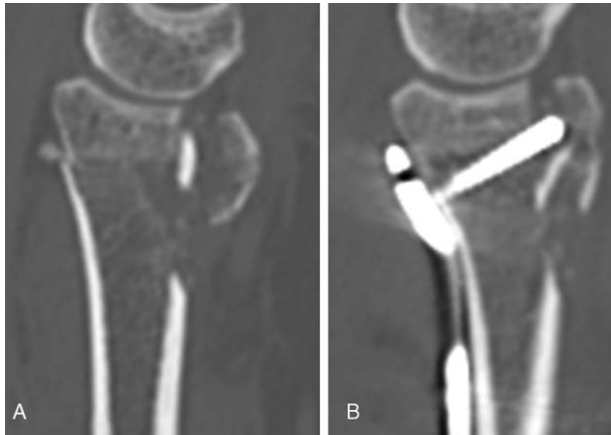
A representative case of intra-articular distal radius fracture treated with the standard volar locking plating technique. Preoperative (A) and postoperative (B) sagittal-view CT. Postoperative sagittal-view CT shows a residual articular gap. CT=computed tomography.
